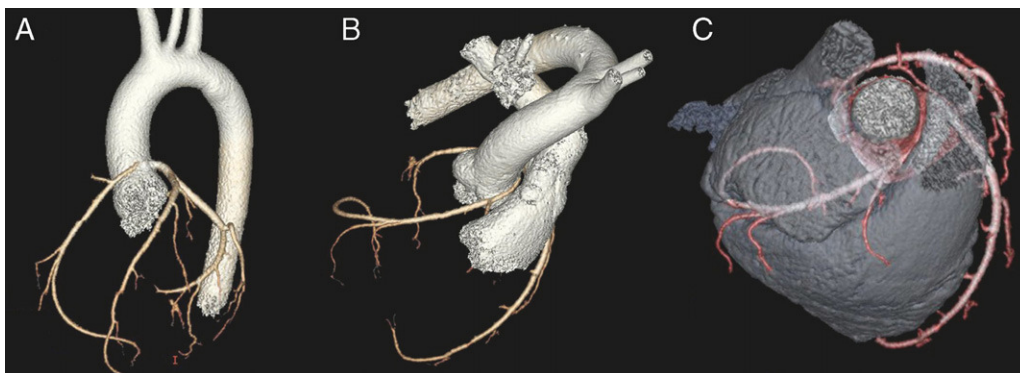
64-slice coronary computed tomography (prospective acquisition) with volume reconstruction: an anomalous right coronary artery arising from the left sinus of Valsalva, decreased caliber and interarterial course.
